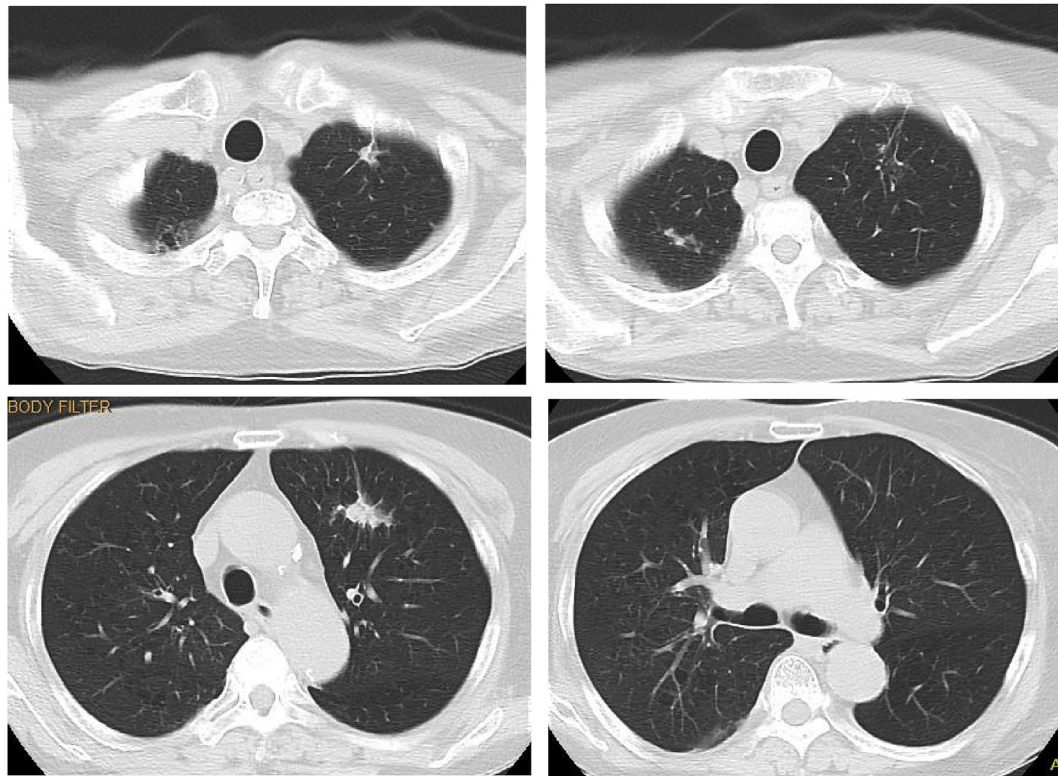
Chest CT images showed multiple nodules without cavities one year after discharge from the hospital.
